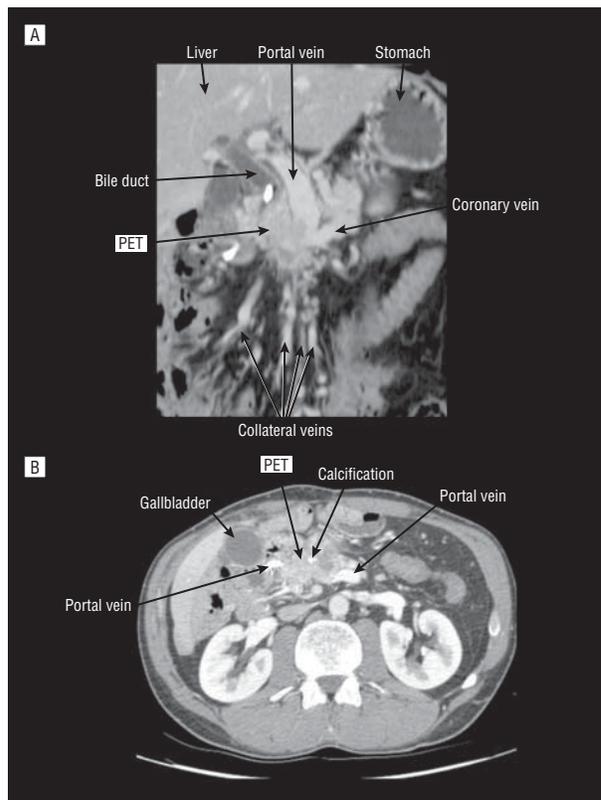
Coronal planar reformation (A) and axial tomogram (B) of a computed tomogram of the same patient with a locally invasive nonmetastatic pancreatic endocrine tumor (PET) obstructing the proximal portal vein. The PET has calcifications. There are extensive collateral veins because of the portal vein obstruction. This patient had the portal vein resected and reconstructed with autologous femoral vein.
